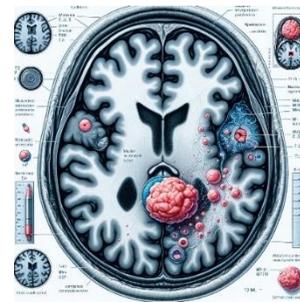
Annotated T1 and T2-weighted Brain MRI Scans showing Rathke's Cleft Cyst
